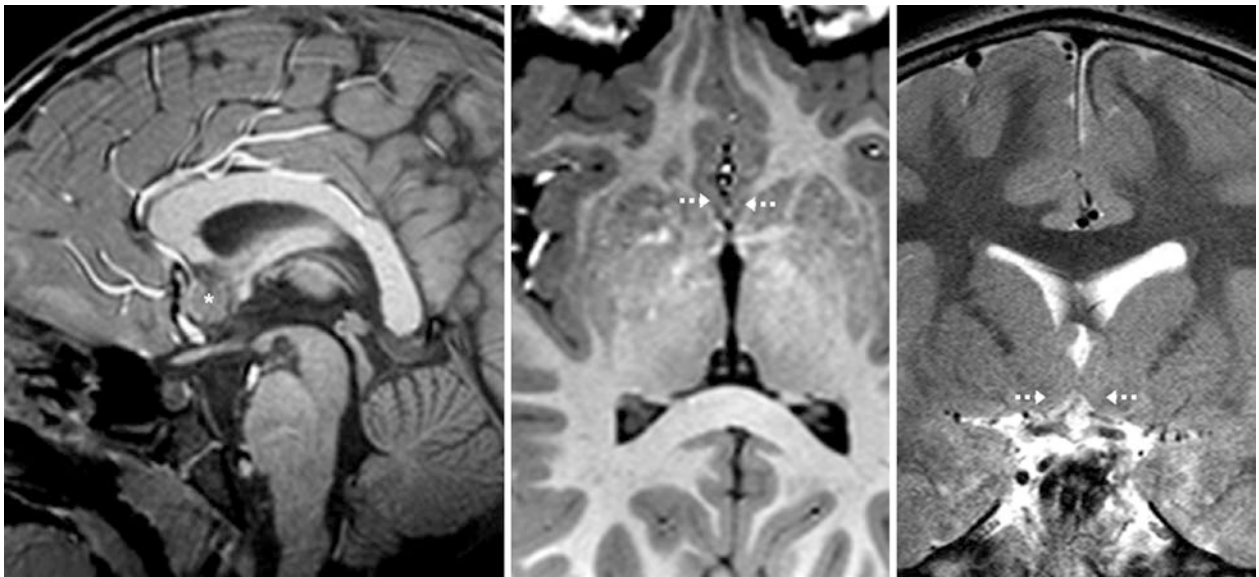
A 7 year old with a 3T MRI that was performed for developmental delay. There is a subcallosal pseudomass (*) on a midline sagittal T1WI (left). Axial T1WI (middle) and coronal T2WI (right) do
